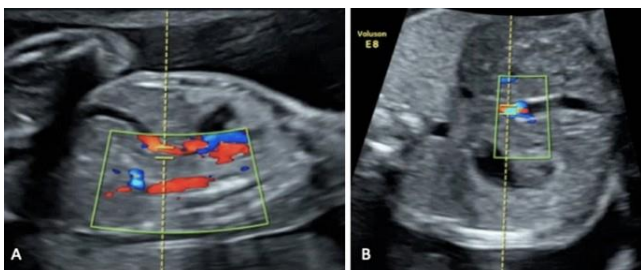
Ductus venosus Doppler flow acquisition in sagittal (a) and axial (b) planes. Melber,⁹
